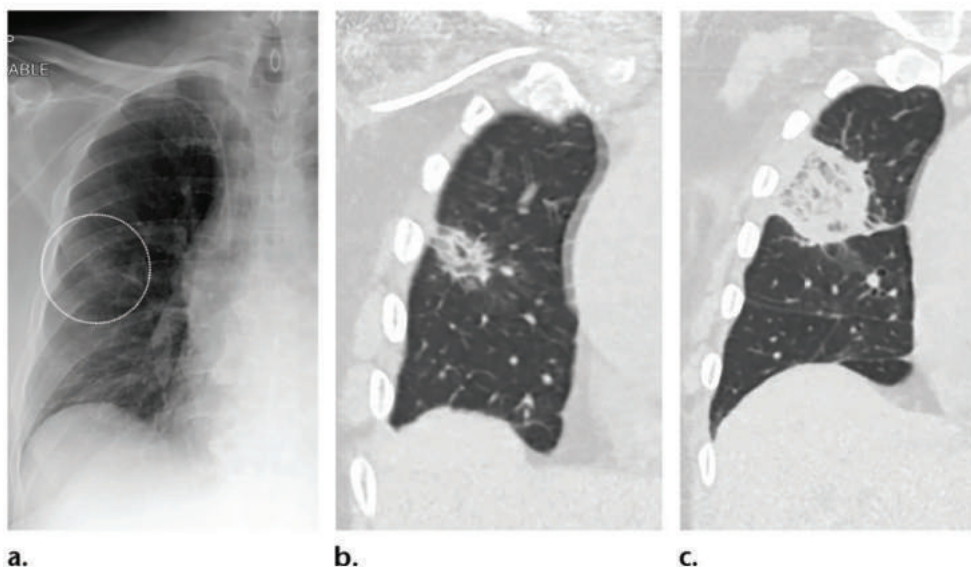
(a) Frontal radiograph of the right lung shows a faint area of ground-glass opacity (dotted circle); (b) Coronal CT image obtained an area of nodular ground-glass opacity; (c) Coronal CT image shows enlargement of the lesion with development of the reverse halo sign.²²
